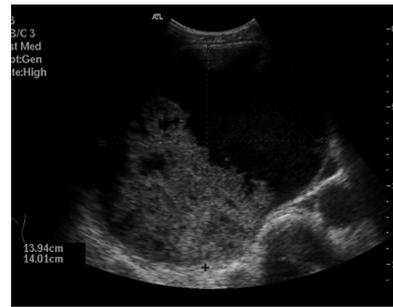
Abdominal ultrasound of a complicated liver cyst showing a well defined hypoechoic lesion with solid appearing blood clot contents.
